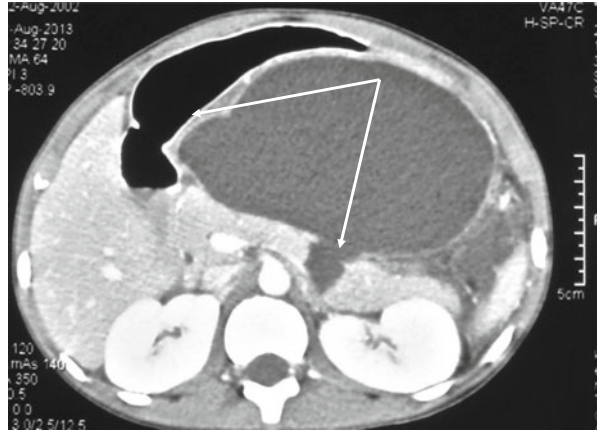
A 34-year-old man presented 4 weeks after sustaining blunt abdominal trauma following a boxing bout. On ultrasound there was a suspicion of injury to the pancreas. MRCP showed a large collection in relation to the tail of pancreas due to an injury to the tail of pancreas. He was stable and was offered surgery after 4 weeks due to pressure effects
